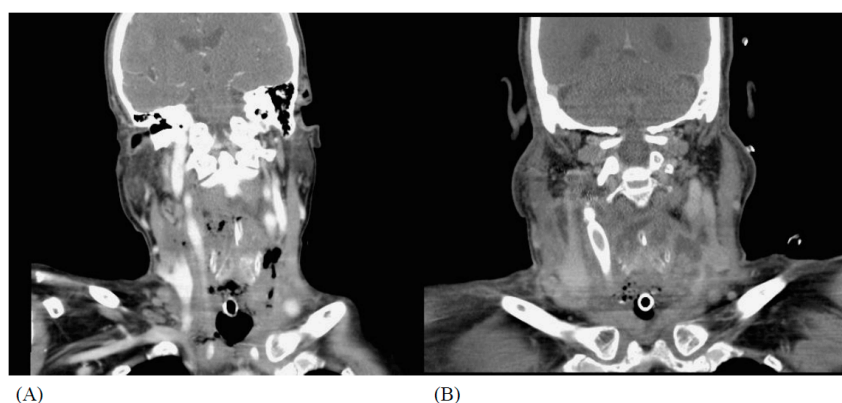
(A) Computed tomography of case 2. The thyroid cancer encased the right common carotid artery (CCA) and external carotid artery (ECA). (B) Stent graft insertion and coil embolization over right carotid artery.
